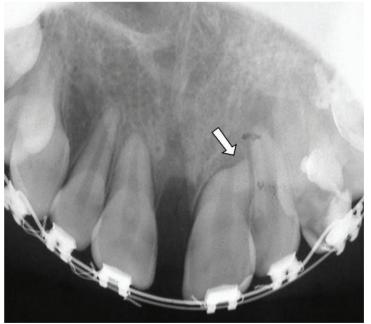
The occlusal radiograph after 27 months from Le Fort 1 operation shows a periapical radiolucency associated with the maxillary lateral incisor tooth and the loss of lamina dura at the distal aspect of the root of the central incisor (arrow). The extensive root resorption of the central incisor and slight root resorption of the lateral incisor can be seen.
